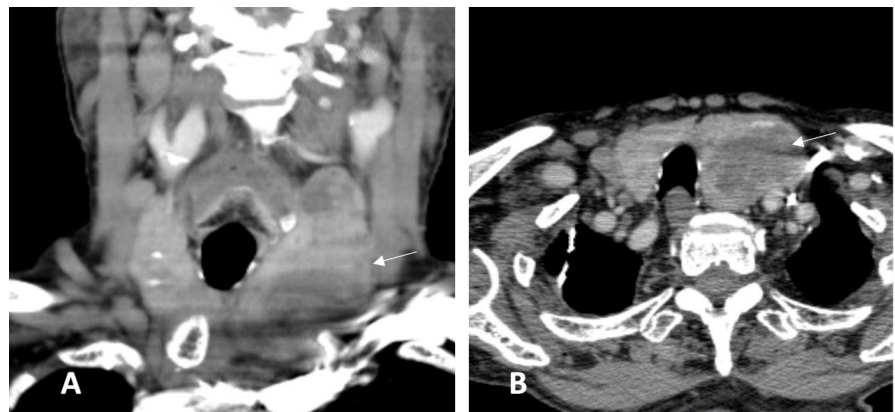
Pre-procedural computed tomography in (A) coronal and (B) axial planes demonstrates the total size of the substernal left thyroid lobe (white arrow) and the compressive effects exerted on adjacent structures.
